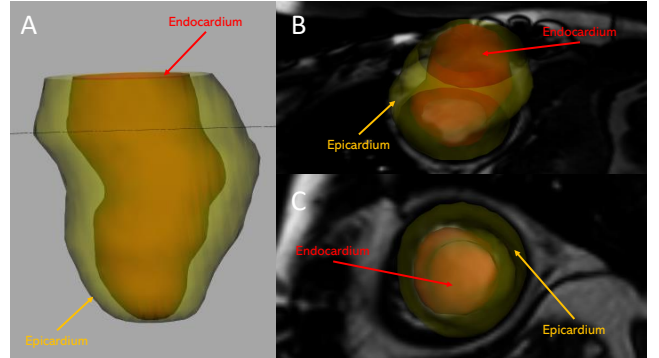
Final 4D reconstruction. We can see the MRI image interposed with the 3D volume of the left ventricle, with the endocardium in red and the epicardium in yellow.
